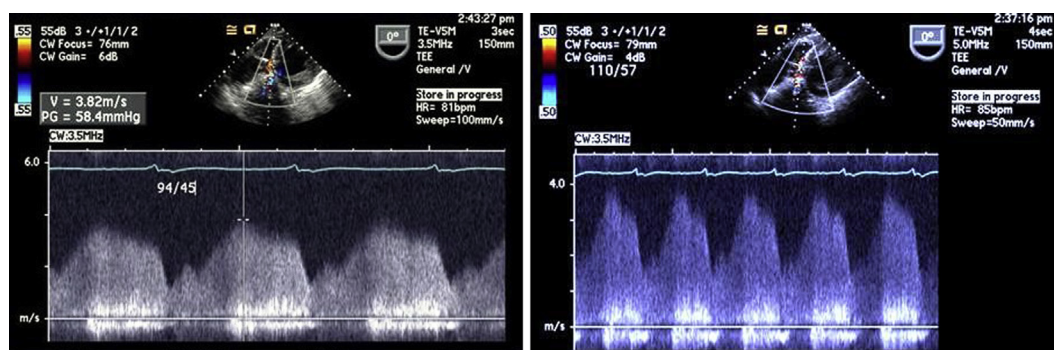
TEE showing a high-velocity, unidirectional left-to-right shunt on transgastric transesophageal views.
